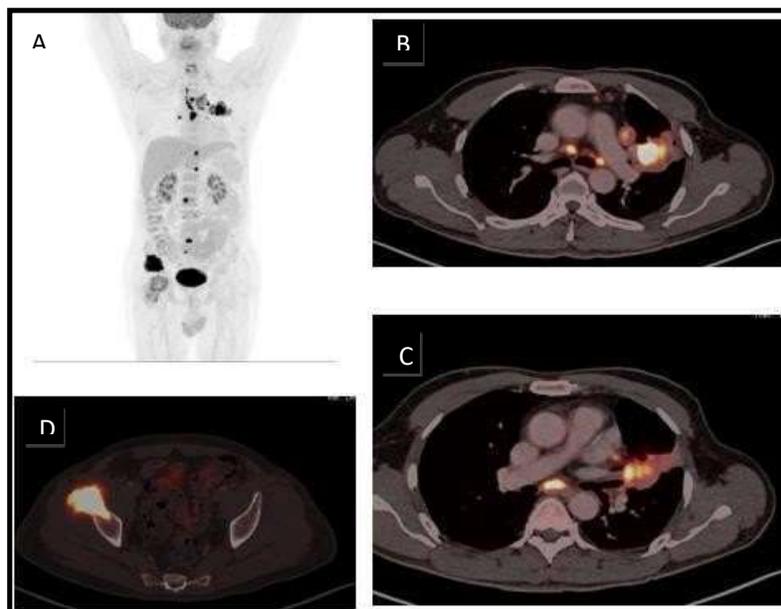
A- MIP image, B- Fusion image of F-18- FDG PET/CT in a 57 year old male with poorly differentiated lung adenocarcinoma of upper lobe of left lung, measuring 2.9 x 2.7 cms. SUVmax- 20.7, SULpeak- 13.7, SUVmean- 11, MTV- 6.3, TLG- 71 with nodal and distant metastases (Stage IVB). C- Metabolically most active regional subcarinal node and D- Distant skeletal metastasis in the right ilium. The patient tested positive for EGFR mutation.
